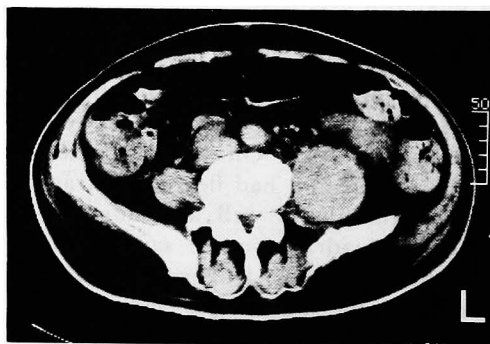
Precontrast CT scan shows diffuse enlargement of left psoas muscle in Case 3.
